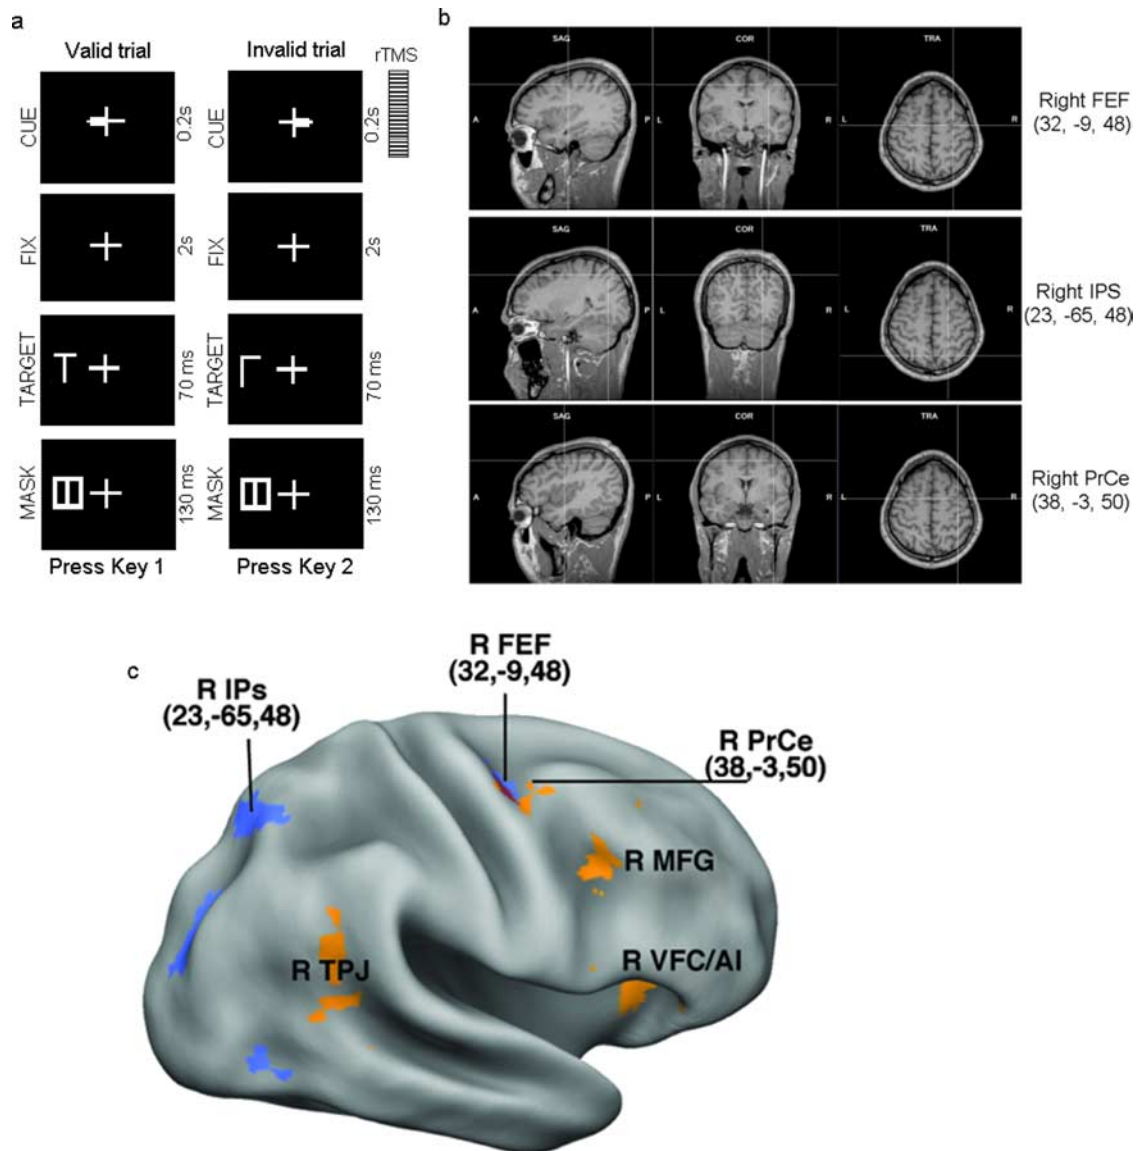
Task and rTMS localization. *a*, Sequence of events during a trial. *b*, Magnetic resonance imaging (MRI)-constructed stereotaxic template showing the sagittal (*a*), coronal (*b*), and axial (*c*) projections of the three rTMS sites on the right hemisphere. *c*, Inflated view of right hemisphere atlas brain with regions of dorsal and ventral attention network as in meta-analysis of He et al. (2007). Regions with coordinates are stimulated with rTMS in this experiment.
